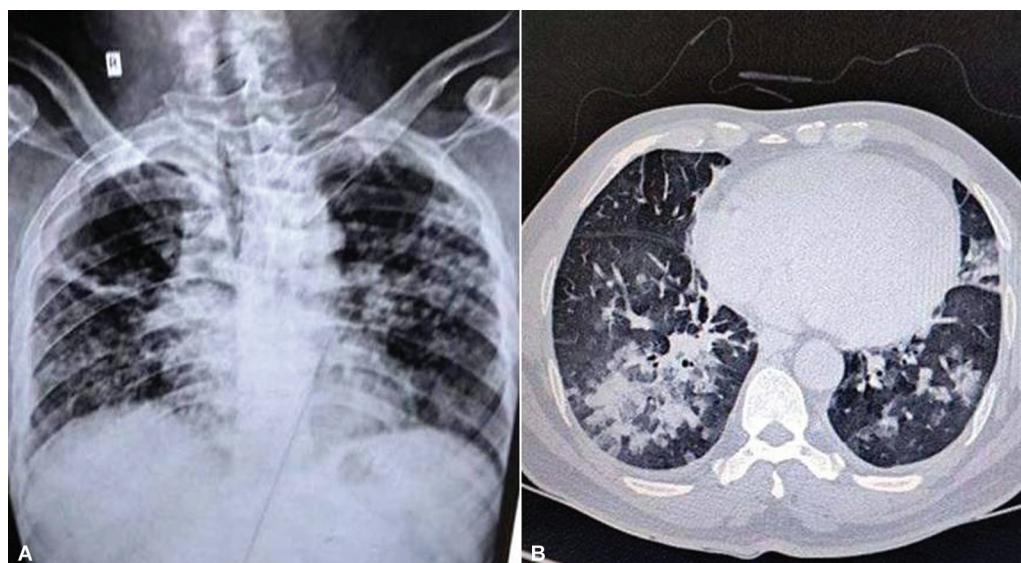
(A, B) Chest X-ray (CXR) and high-resolution computed tomography (HRCT) of the patient indicating post-coronavirus disease (COVID) fibrotic changes with lung involvement.
